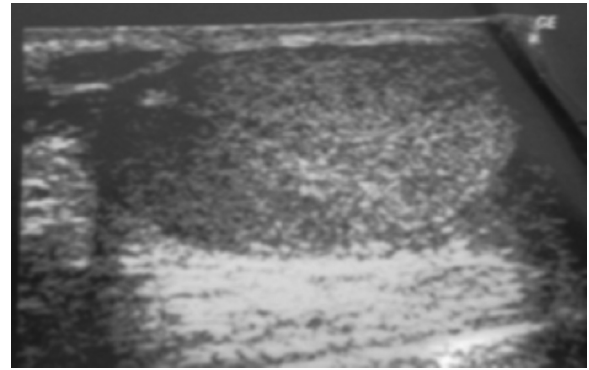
Scrotal ultrasound image showing a multi-cystic lesion attached to the right epididymis.
